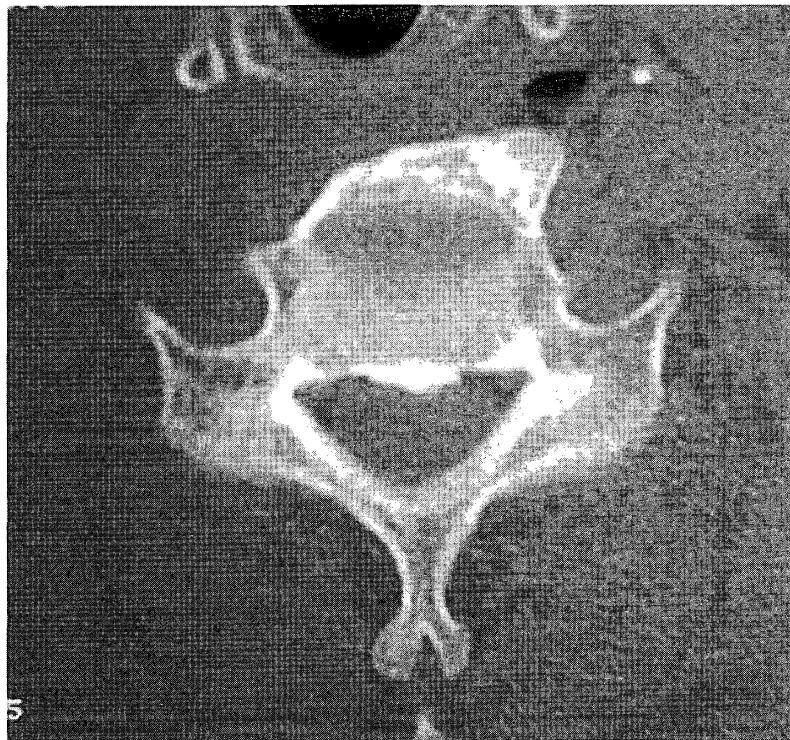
Postoperative axial CT scan with bone algorithms, showing the disappearance of the osteophytes.
